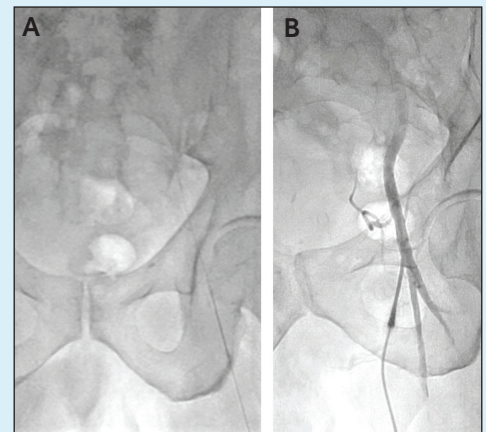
Ultrasound-guided access of the CFA (A). Confirmation of CFA access with a sheathogram (B).
